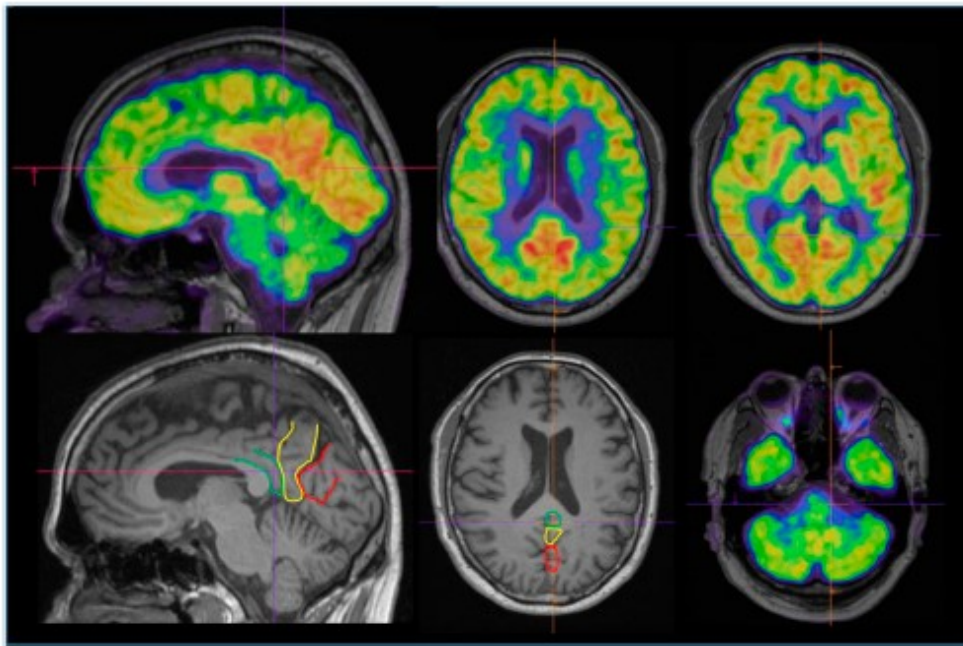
Standardized reading approach of 18F-FDG-PET. Abbreviations: MRI = magnetic resonance imaging; PCC = posterior cingulate cortex; 18F-FDG-PET = 18F-fluoro-deoxy-glucose positron emission tomography; MRI and 18F-FDG-PET image displayed in sagittal and axial plane in Scenium with orientation through PCC (green), precuneus (yellow) and cuneus (red).
